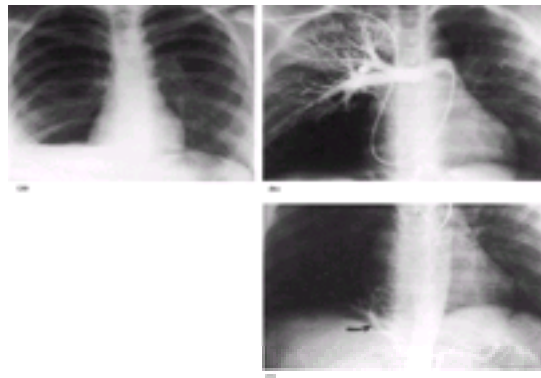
(a) Chest radiograph of a 12-year-old girl referred for evaluation of the right lower lobe. She had an episode of pleuritic pain and right lower lobe pneumonia 5 months before, treated with penicillin. After recovery the chest radiograph showed a remaining pulmonary effusion, an area of 'scarring', and hyperlucency of the right lower lobe, all identified on pulmonary tomograms as well. An underlying anatomic anomaly was suspected. (b) Pulmonary arteriogram demonstrates perfusion of the right upper and middle lobe but no perfusion of the lower lobe by the pulmonary artery. (c) Aortogram demonstrates perfusion of the right lower lobe by arteries arising from the aorta (arrow). At surgery this was confirmed and a right lower lobectomy was performed.
